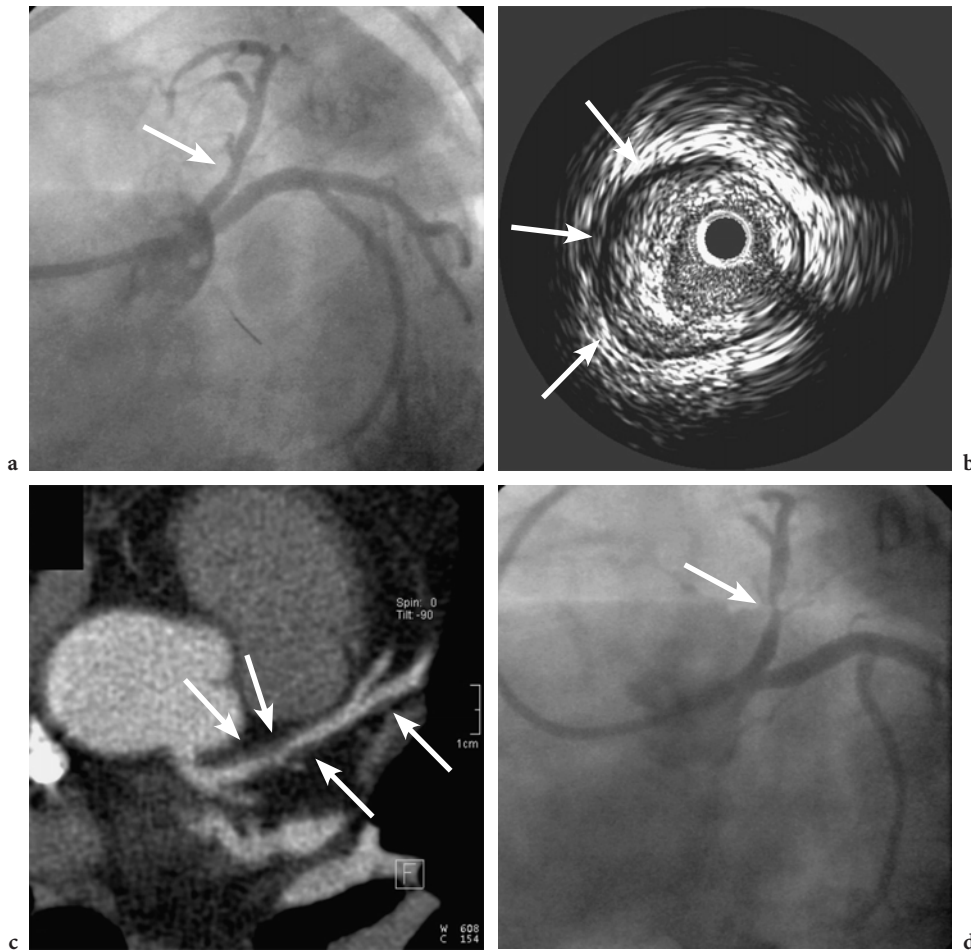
Case report: A 63-year-old female patient was admitted to the hospital because of chest pain at rest (unstable angina). Coronary angiography showed only non-significant stenosis of the proximal LAD (a). The patient was examined using intravascular ultrasound (IVUS) (b) and 16-slice CT (c). Both showed substantial amounts of non-calcified atherosclerotic plaque in the proximal LAD (*arrows*). The patient was discharged on aspirin and lipid-lowering medication. Two months after the first admission, she was admitted to the hospital again with an acute non-ST-elevation myocardial infarction. Immediate coronary angiography showed a tight stenosis in the proximal LAD (d, *arrow*). Plaque rupture had occurred at a site that had been free of significant stenosis but with substantial plaque burden, undetected by invasive angiography, at initial presentation.
